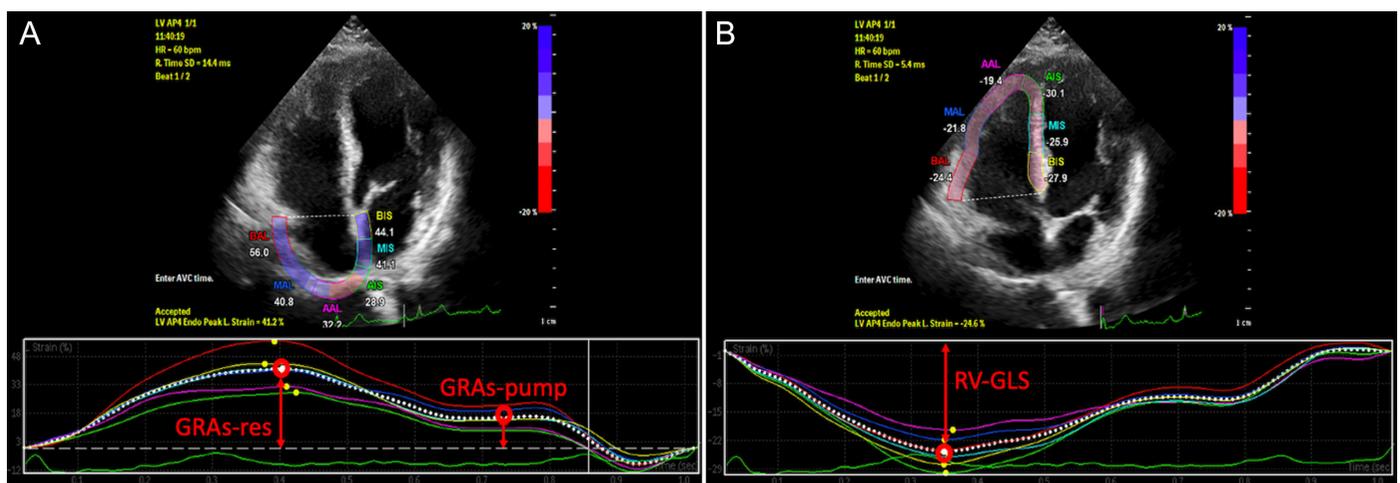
Right ventricular global longitudinal strain (RV GLS), global longitudinal right atrial strain during ventricular systole (GRAs-res), and global longitudinal right atrial strain during late diastole (GRAs-pump) were measured by speckle-tracking echocardiography analysis of 6 consecutive myocardial segments in the RV and the RA.
